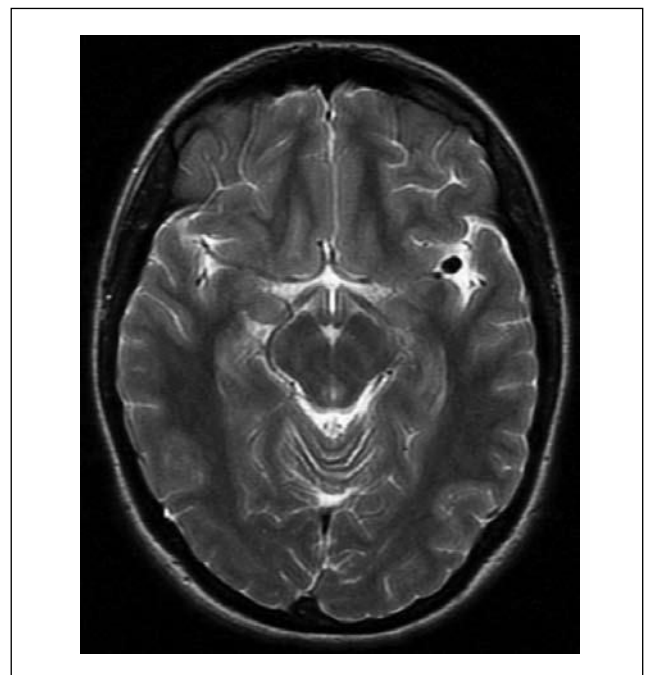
A 16-year-old girl with headaches, without neurological signs and symptoms. MRI, FSE/T2-weighted image, axial plane. An aneurysm in the left middle cerebral artery bifurcation.
